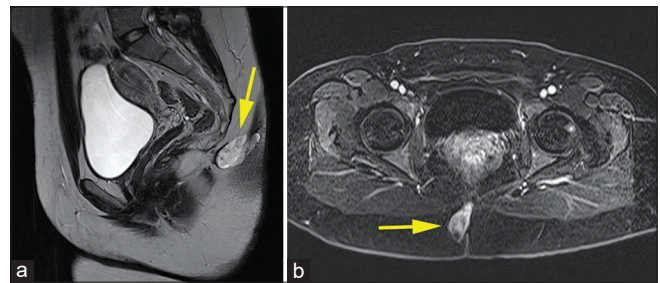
Preoperative magnetic resonance imaging (MRI) imaging. MRI of pelvis demonstrating soft tissue mass centered within the right hemigluteal region. Sagittal T2-weighted image (a) and axial T1-weighted postcontrast image (b) is shown with arrowheads indicating location of the mass.
